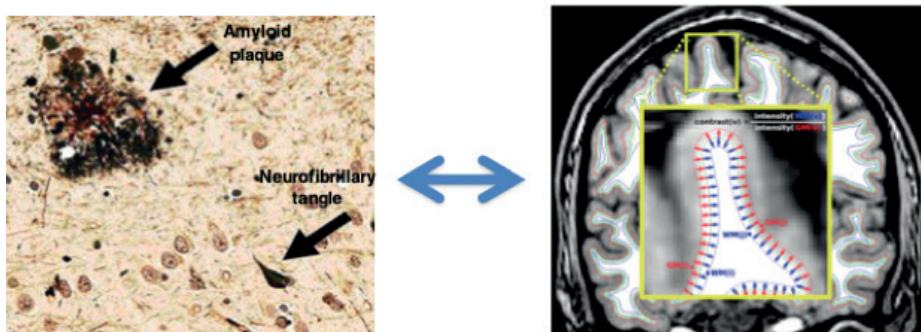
PLD1 impacts both Alzheimer's disease neuropathological hallmark features and gray-white matter tissue contrast on T1-MRI. Neuropathology image adapted from Jack et al, Radiology, 2012 [215], and T1-MRI GWC calculation example adapted from Lewis et al, Neuroimage, 2018 [216].
